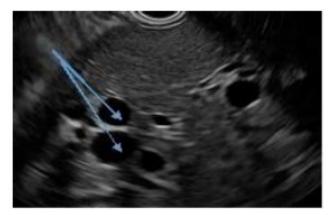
Upper endoscopic ultrasound. The liver with dilated intrahepatic biliary ducts (blue arrows).
